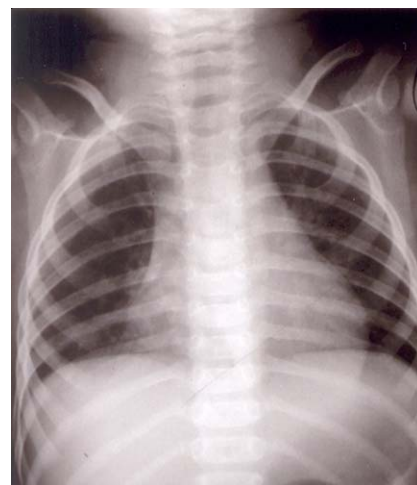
Chest radiograph at 1 year after completion of treatment showing completion resolution of infiltrates
